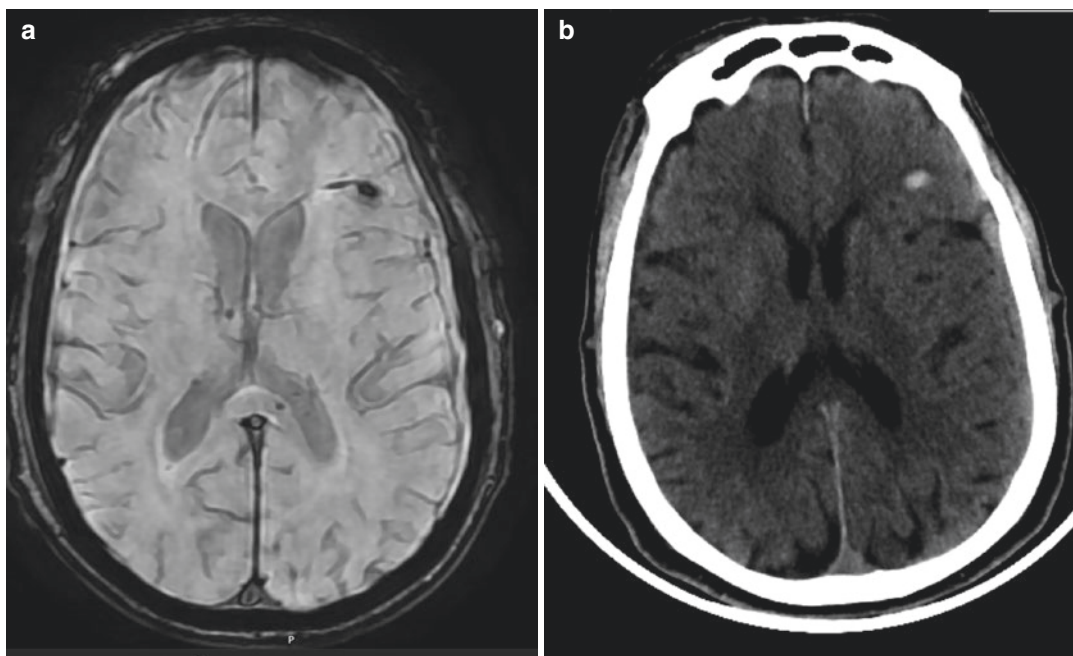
A vascular malformation accompanied with a subacute subdural hematoma. Axial susceptibility weighted imaging sequence magnetic resonance imaging (a) and CT (b) images
